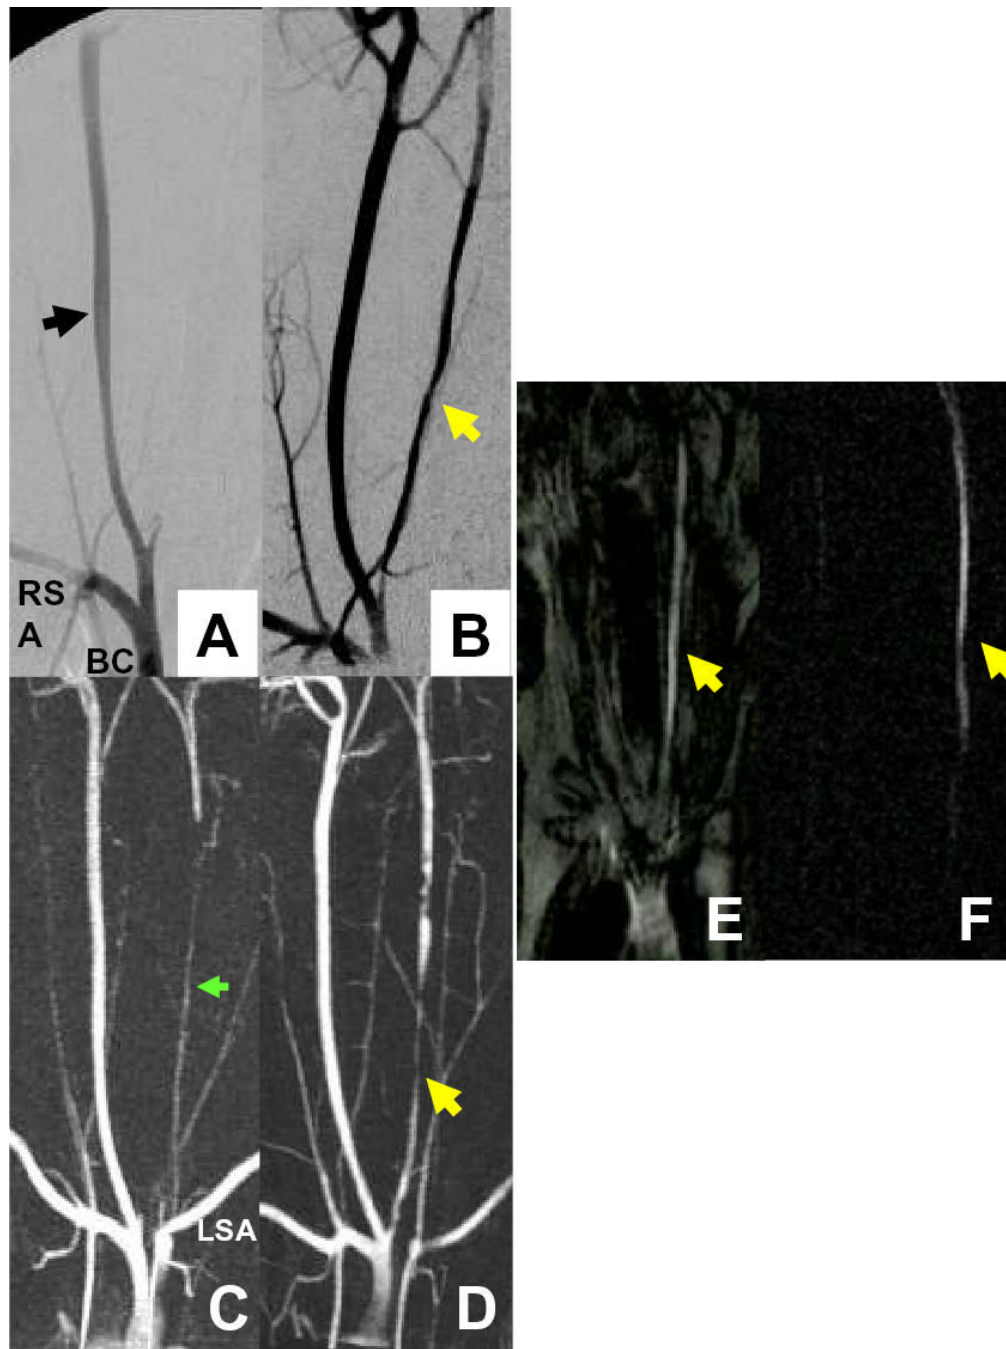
Multimodal angiography before and after CTO recanalization. (A,B) Pre and post intervention AP projection subtraction X-ray demonstrates right carotid artery (black arrow) and patent post-intervention left carotid artery (LCA) CTO (yellow arrow). (C,D) Pre and post intervention CEMRA in the AP projection. Pre-intervention, the distal artery reconstitutes via cerebral collateral circulation with contribution from the left vertebral artery (green arrow) arising from the left subclavian artery (LSA). (E,F) Selective real-time angiography gives immediate confirmation of successful recanalization into the patent LCA (yellow arrows) with saturation prepulse applied (E) and with better contrast with subtraction maximal intensity-over-time projection (F). AP = antero-posterior, CEMRA = contrast enhanced MRA
